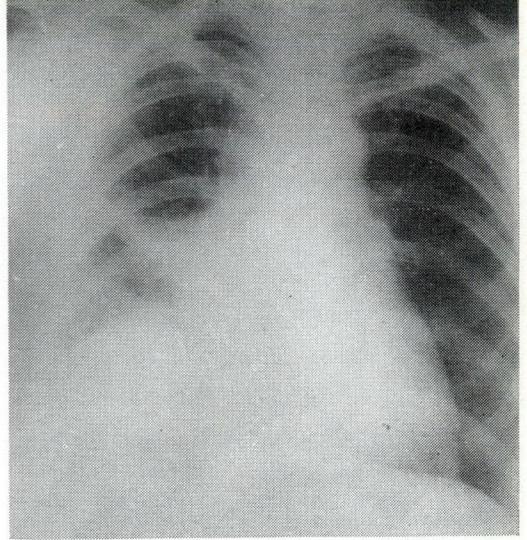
Case 5—malignant teratoid cyst. Post-operative chest radiograph.
